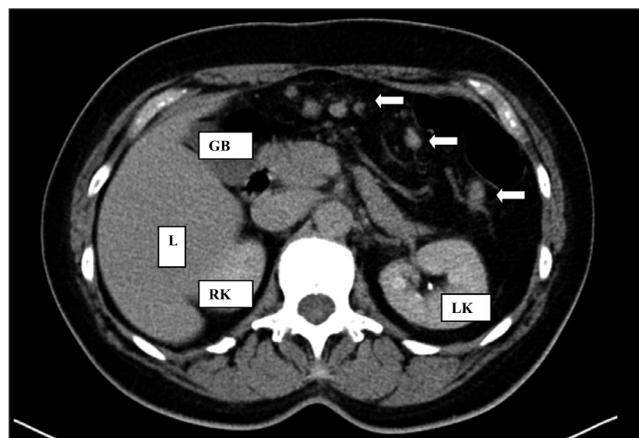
Axial CT of the abdomen in an adult with post-traumatic splenectomy in the past showing small multiple oval splenic implants (arrows) in the abdominal cavity (L: liver; LK: left kidney; RK: right kidney; GB: gallbladder).
